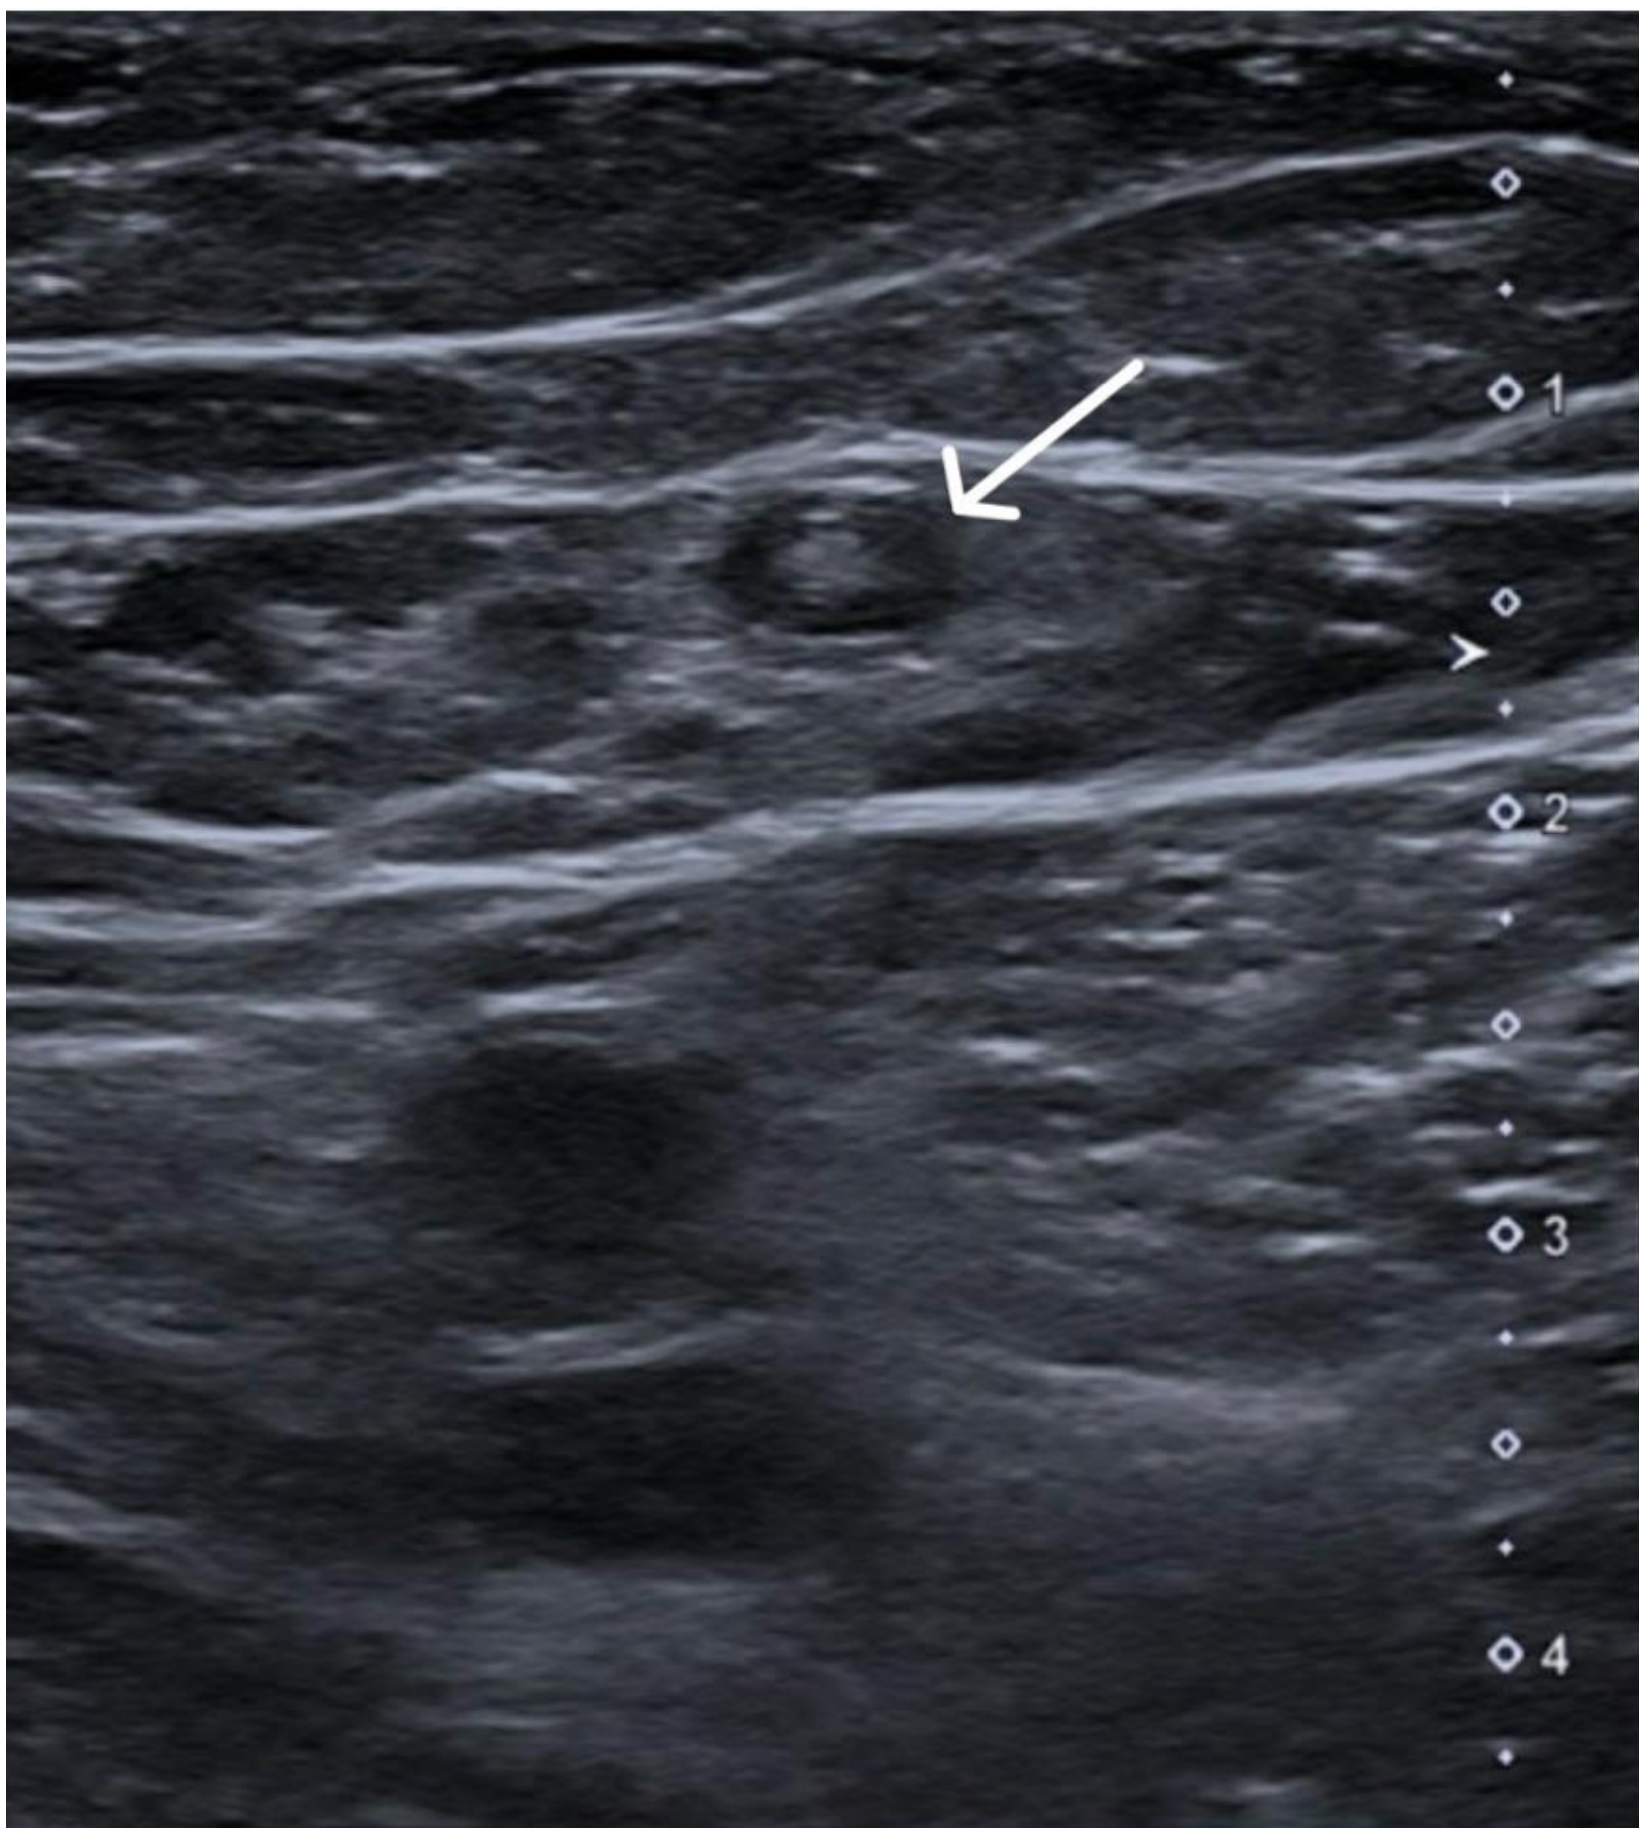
Duplex ultrasound of the anterior accessory saphenous vein showing superficial vein thrombosis. The affected segment appears non-compressible with internal echoes consistent with thrombus and increased echogenicity. Courtesy of Dr Mahmoud Al-Najjar, Australian Vascular. Used with permission.
